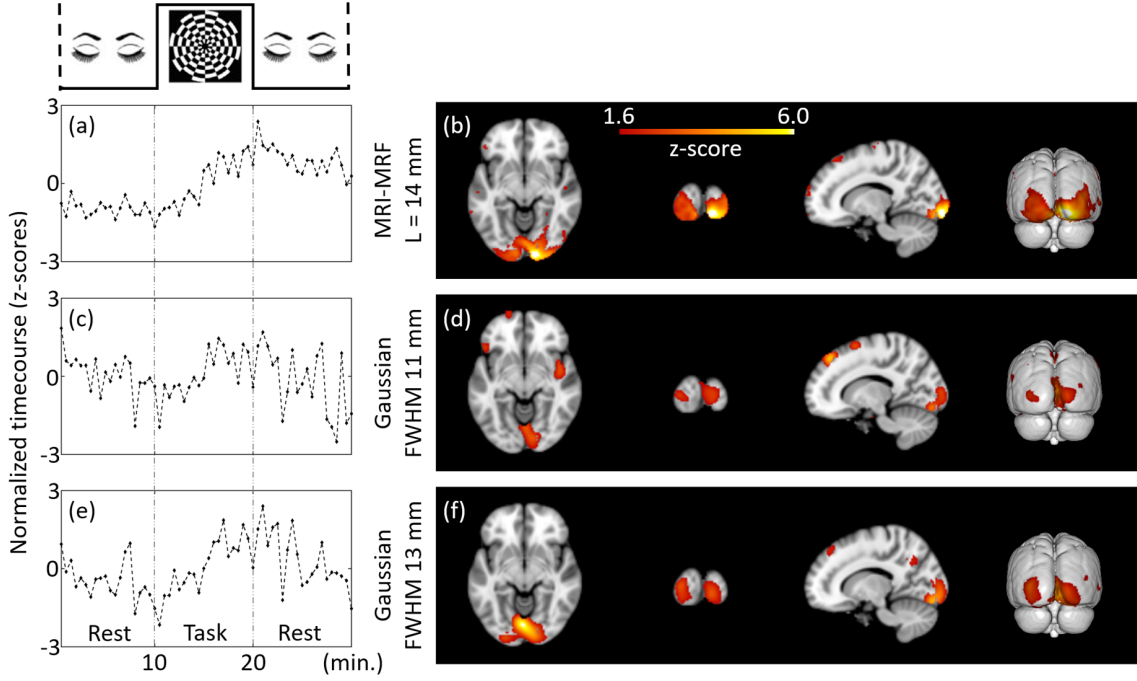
Comparison of brain activation maps and timecourses for subject-level analysis with all the fPET frames:  $T_{bin} = 30$  s and  $DF = 1$  at MNI coordinate (14, -94, -8). The independent components estimated from the filtered fPET images using different schemes are provided. The task paradigm is shown in (a). ICA maps and timecourses: top to bottom: MRI-MRF prior with  $L = 14$  mm (b) and (c), Gaussian smoothing with  $FWHM = 11$  mm (d) and (e), Gaussian smoothing with  $FWHM = 13$  mm (f) and (g).
